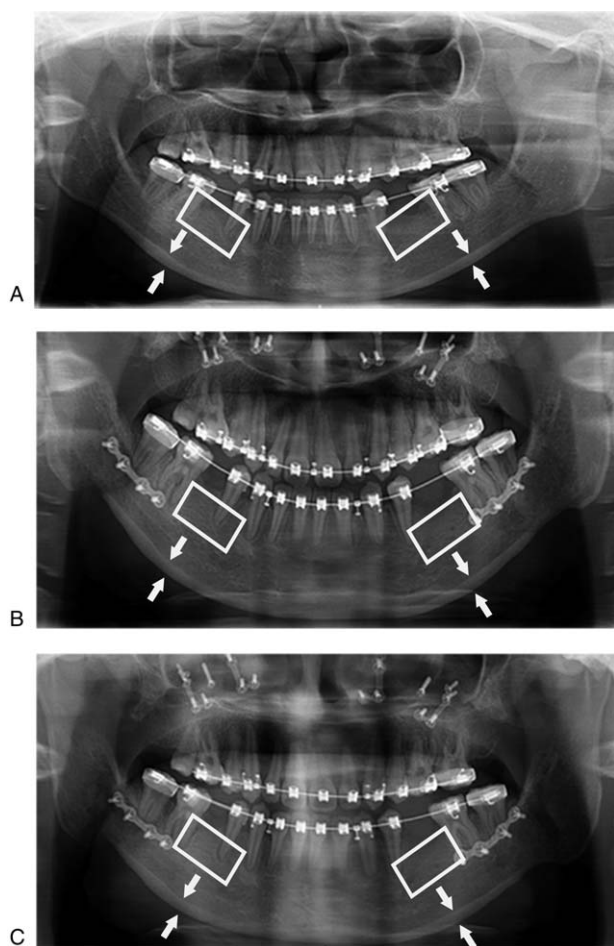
Cortical bone in the premolar mandibular region (white arrow), trabeculae bone in the premolar region (white box). (A) Preoperational panoramic radiograph; (B) panoramic radiograph (3 months after BSSRO); (C) panoramic radiograph (6 months after BSSRO). BSSRO = bilateral sagittal split ramus osteotomy.
